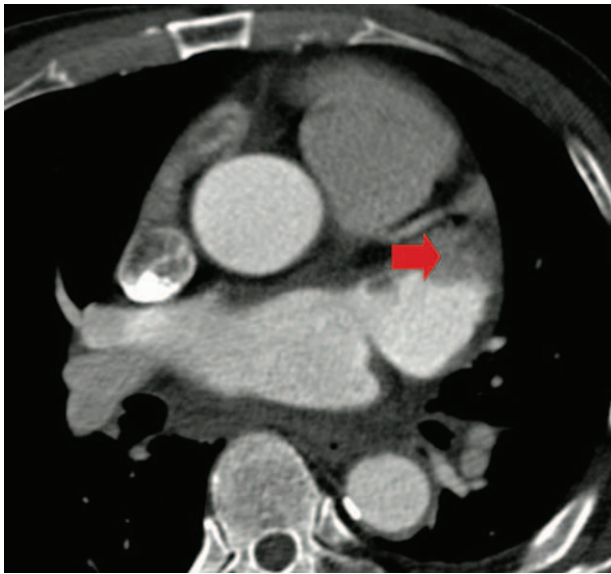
Contrast-enhanced computed tomography showed suspicious thrombus in left atrial appendage (indicated by red arrow).
